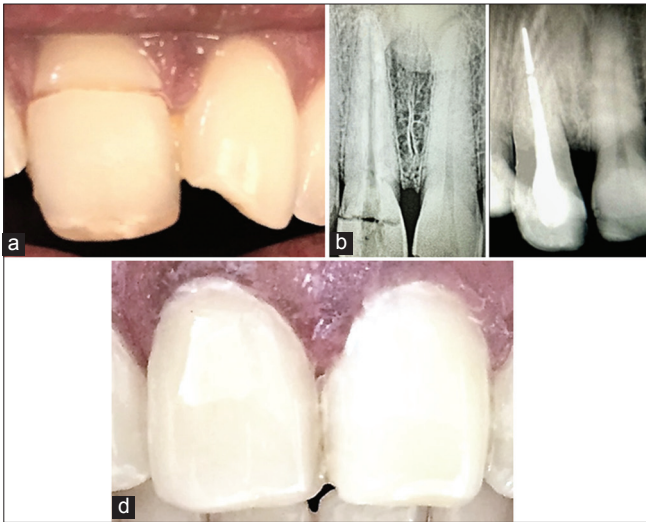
(a and b) Pre-operative clinical and radiographic images, (c) post operative radiographic image, and (d) post-operative clinical photograph
